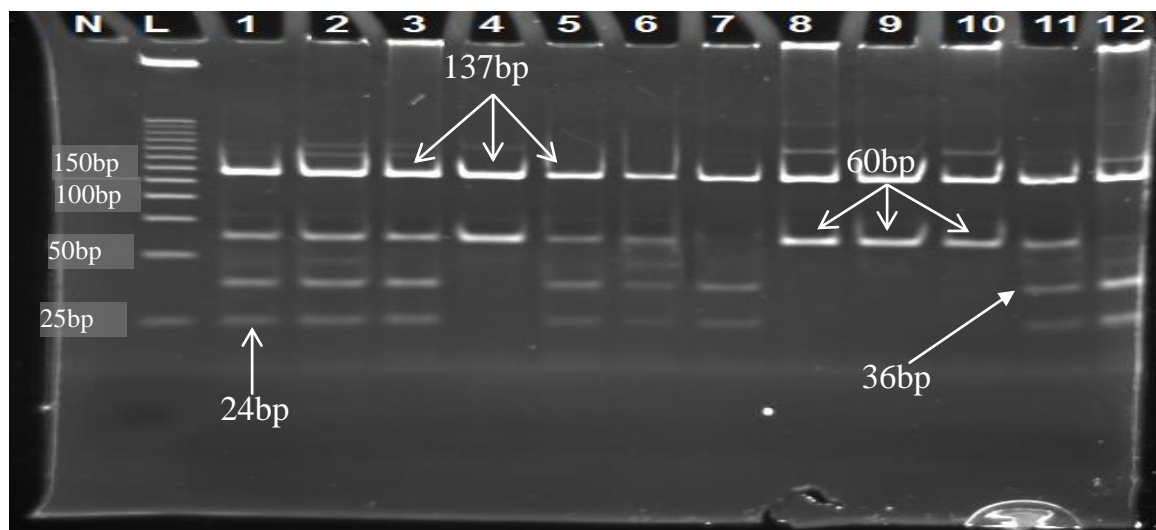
Genotyping of rs653178 by the designed PCR-RFLP method . (lanes : N = internal negative control ; L=25 bp step ladder ; 1,2,3,5,6 and 11= CT genotype ; 4,8,9 and 10 = TT genotype ; 7 and 12= CC genotype .
